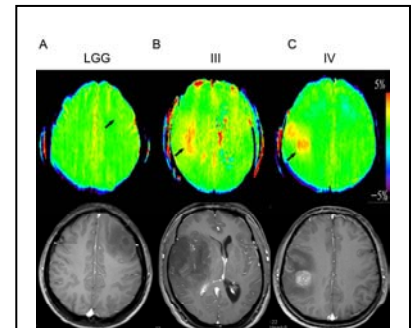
(A) Oligodendrocytoma (WHO grade II) of the left frontal lobe in a 27-year-old woman was not enhanced with post-contrast T1WI. The APT signal intensity was low (arrow). (B) Anaplastic astrocytoma in a 39-year-old man (grade III). There was a minor enhancement in tumor core in post-contrast T1-weighted image, but a obviously high signal intensity on the APT image (arrow). (C) Glioblastoma multiforme in a 37-year-old man (grade IV). There were two enhancing tumor cores in the post-contrast T1WI image, which were hyperintense in the APT image (arrow).
